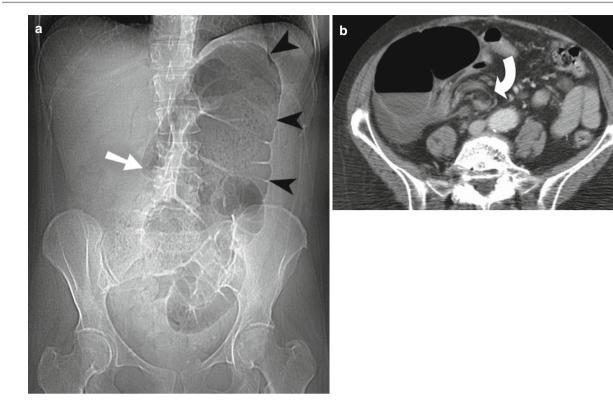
Cecal volvulus. (a) Plain x-ray of the abdomen demonstrates dilatation of the cecum (*arrowheads*) which extends to the left upper quadrant. The bowel gas transition is present in the ascending colon
